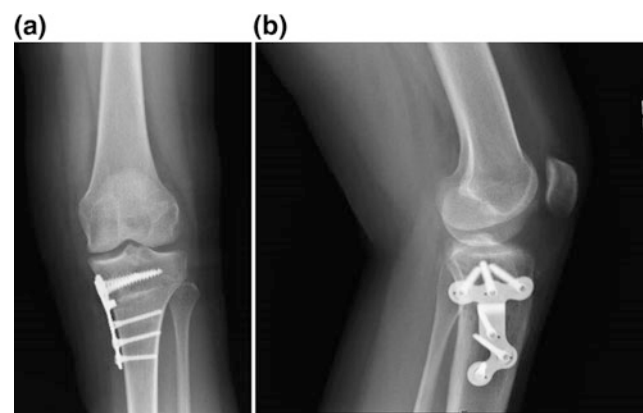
Postoperative AP (a) and lateral (b) radiographs of a 20-year-old female who required high tibial osteotomy to correct varus malalignment and elevated tibial slope following failed anterior cruciate ligament reconstruction
